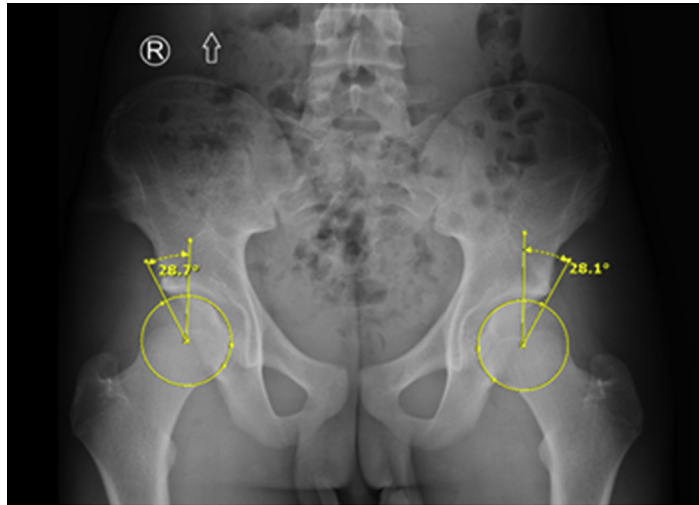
AP pelvis radiograph demonstrating measurement of bi-LCEA in 16-year old male patient with FAI.
